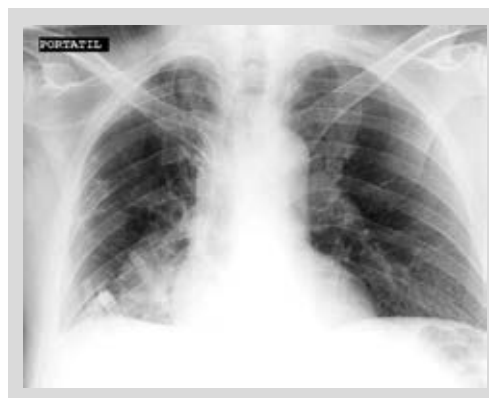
Chest X-ray posterior to octreotide infusion and pleurodesis in the first patient.
